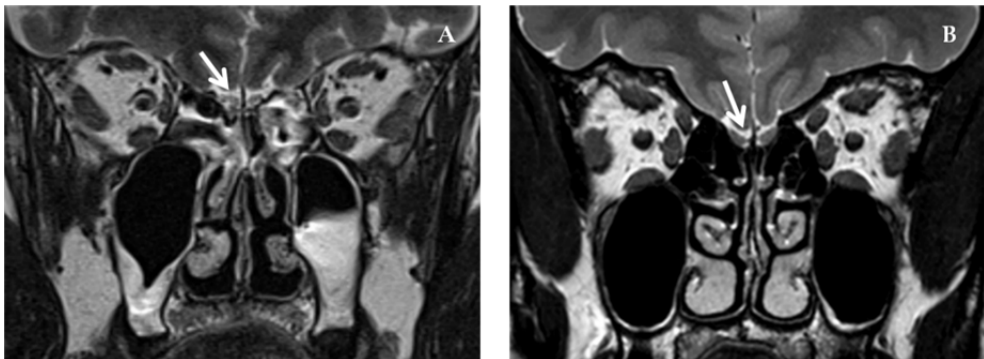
T2-MRI on the coronal plane of patient suffering from CRS (A) and control subject (B). Note that the olfactory bulb (white arrow) of the patient seems smaller than the OB of the control subject.
